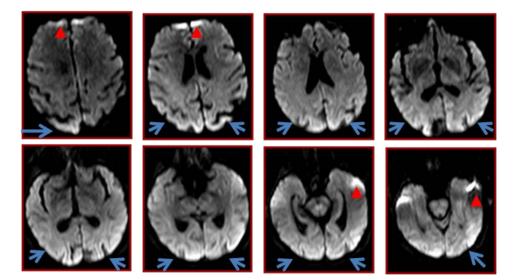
DWI obtained 6 weeks after symptom onset, showing restricted diffusion in the parietal and occipital cortex, the cortical ribbon sign (blue arrows.) Corresponding FLAIR and T2 images did not show changes. The hyperintense changes in the frontal pole and anterior temporal lobes are artifacts (red arrow heads.)
